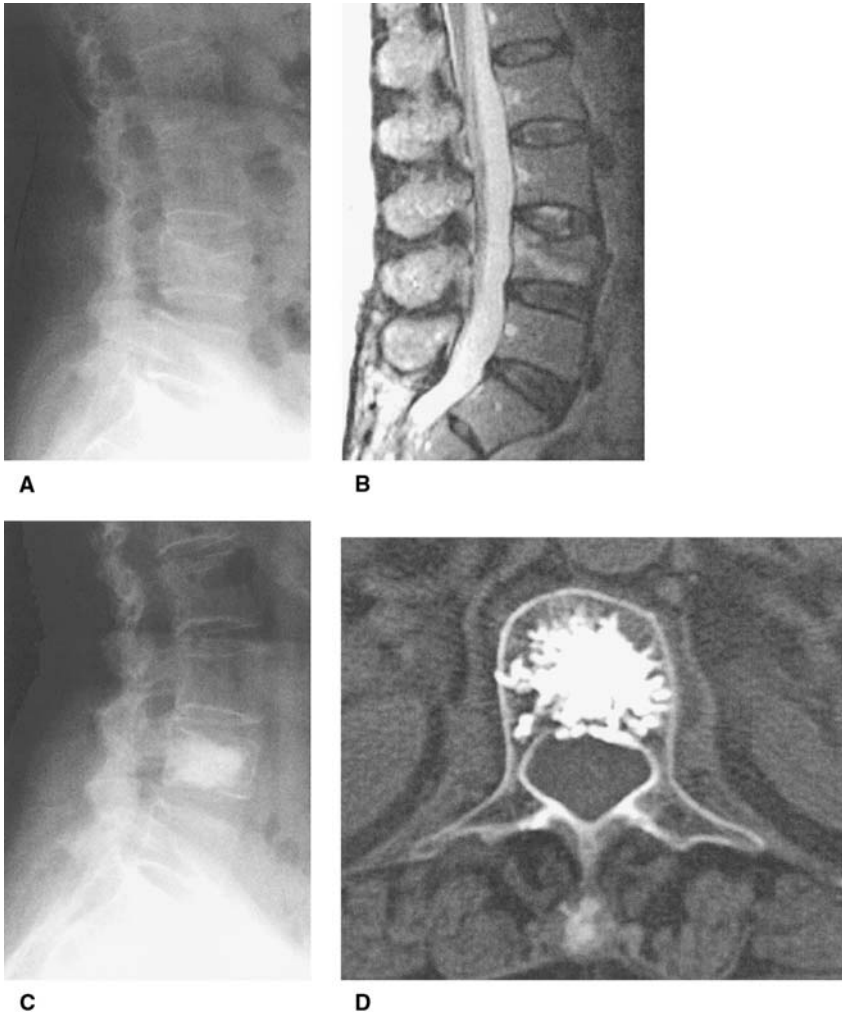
(A) Osteoporotic vertebral compression fracture of L4 in a patient with pain refractory to medication. (B) MRI shows a hyperintense T₂-weighted signal. (C) Vertebroplasty is performed with good filling of the vertebral body and an excellent result. (D) A postprocedural CT scan shows a small leakage of cement into the epidural venous plexus.
